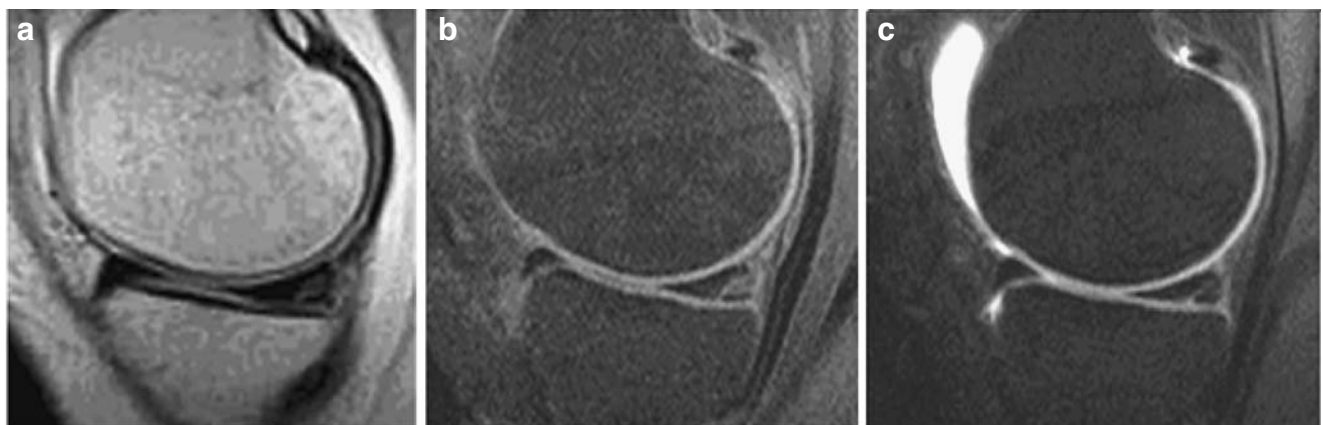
False positive recurrent meniscal tear at MRI/MRA. 0.2-T magnet: sagittal T1-weighted SE image after contrast injection (a); 1.5-T magnet: sagittal T1-weighted fat-suppressed SE image before intra-articular contrast mixture (b), sagittal T1-weighted fat-suppressed SE image after intra-articular gadoterate administration (c).
